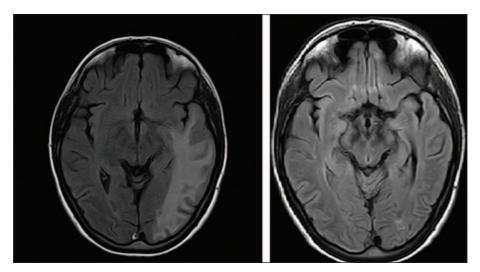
Axial T2-weighted MRI at 35 years old in the described patient showing a left temporo-parieto-occipital hyperintensity, being interpreted as a stroke-like lesion (left). This lesion had disappeared within one year after having become seizure-free at 37 years (right).
